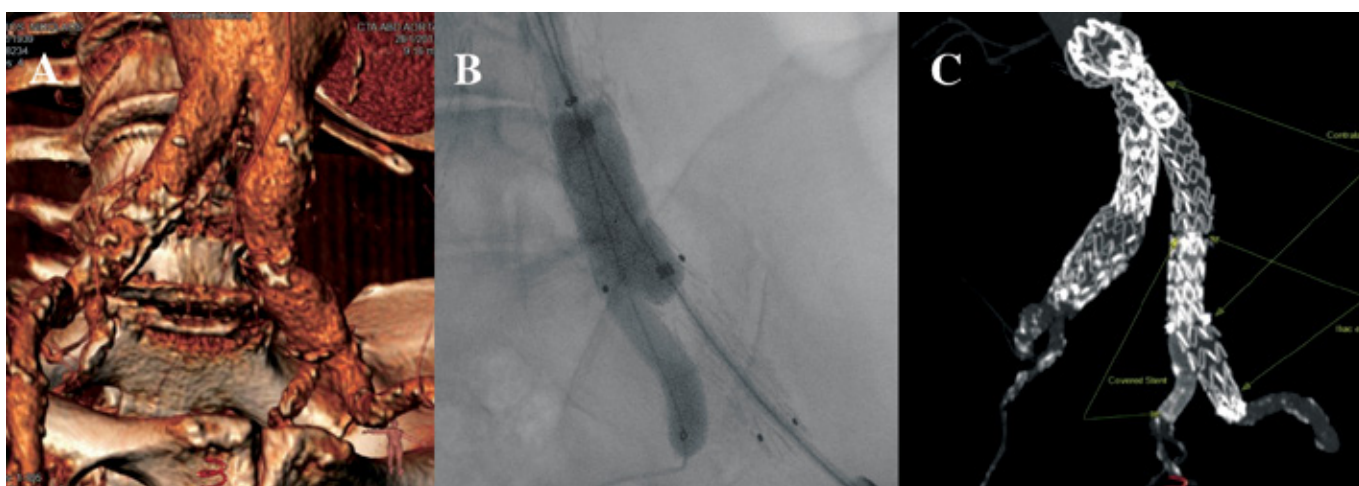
A. CTA showing a large Lt CIA aneurysm with insufficient landing zone, B. Intraoperative image showing the kissing-balloning during the sandwich technique, C. CTA at 2 years after the procedure showing the endografts' configuration after the sandwich technique
